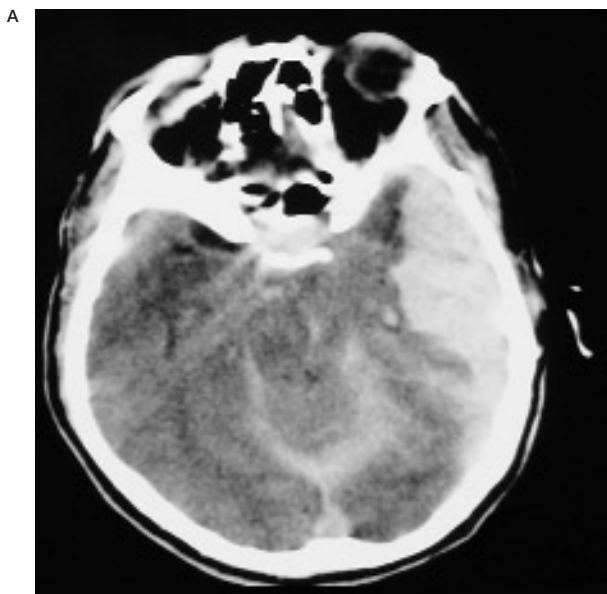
Cranial CT: Non contrast CT showed massive intraparenchymal and extra-axial acute haemorrhage with edema, mass effect, midline shift, uncal and infratentorial herniation. Note the crescent shape of the extraaxial haemorrhage (arrow).
